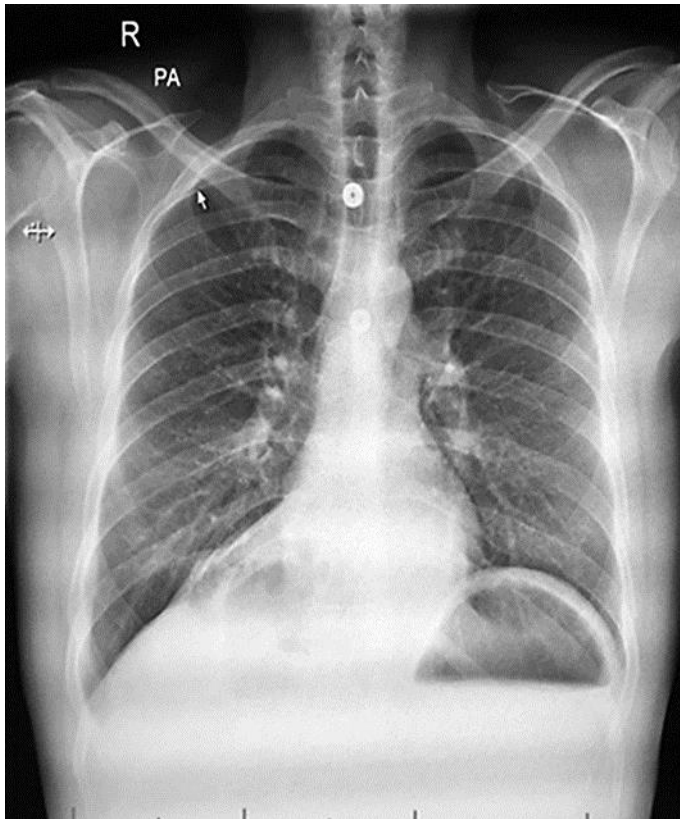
Normal chest X-ray after surgery.
